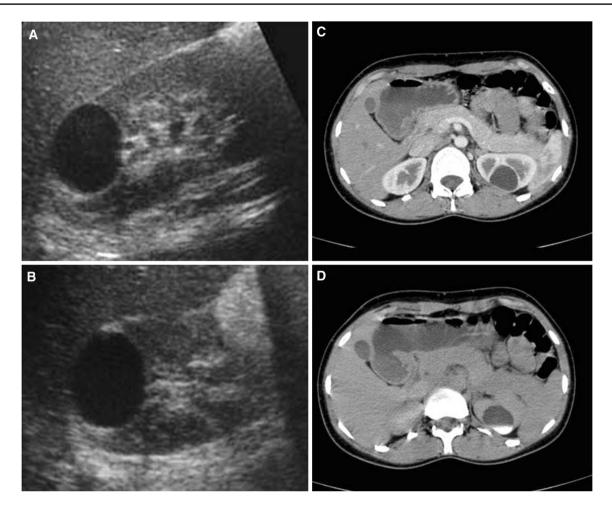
Calyceal diverticulum. Sagittal (a) and transverse (b) ultrasound images of the left kidney show an anechoic cystic lesion in the upper pole. Post-contrast nephrographic and delayed-phase axial CT images (C, D) show there is filling of the contrast within the cystic structure
